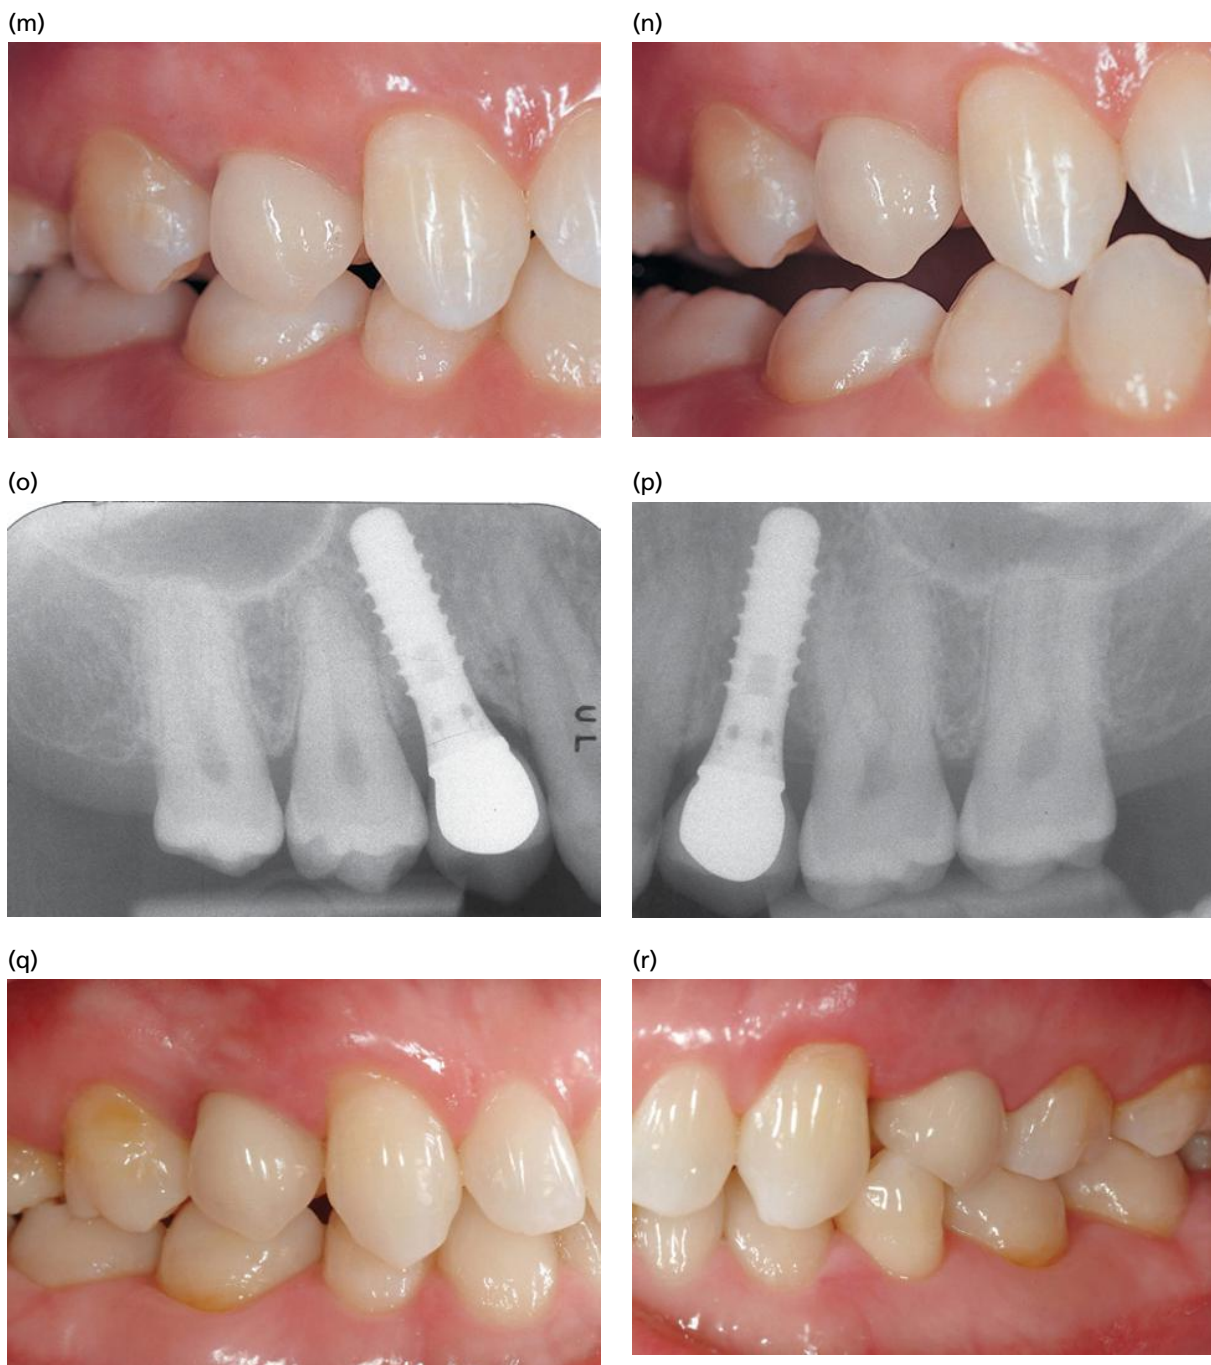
(a) Right lateral view of a 19-year-old female patient, congenitally missing all four permanent maxillary premolars. Note both an inadequate mesiodistal gap width and a reduced interarch distance. (b) Similar situation regarding the interarch distance is present on the patient's left side. (c) Corresponding radiograph underlines the need for additional orthodontic therapy prior to the insertion of an implant in order to optimize the gap width and the inter-radicular distance. (d) Although to a lesser degree, presurgical orthodontic therapy is also indicated for the maxillary left posterior segment.
